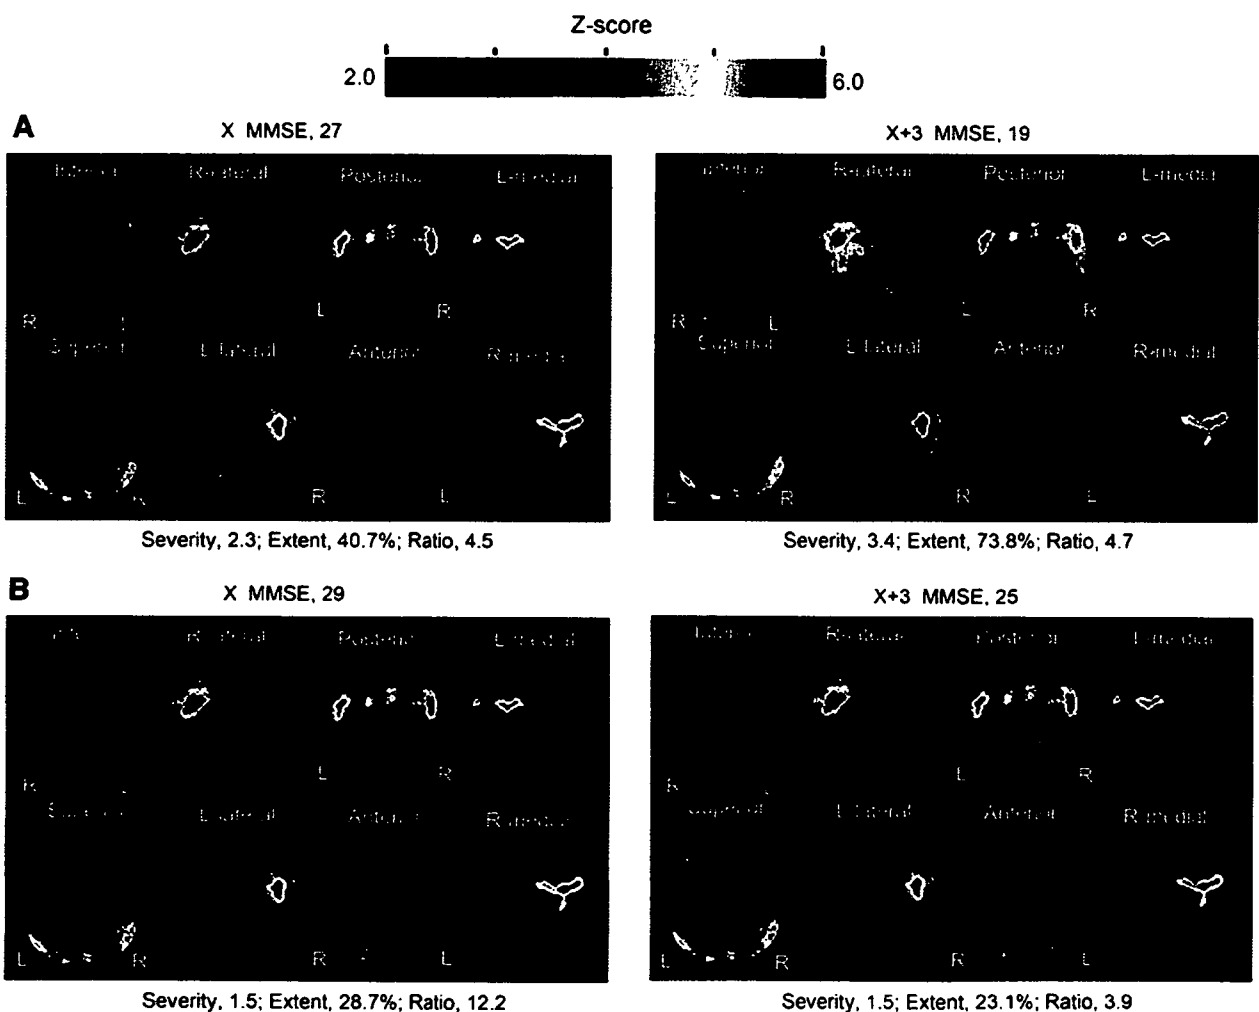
Comparison of z score mapping results for brain perfusion SPECT for converters (from amnesic MCI to AD) and nonconverters over 3 y. (A) For 56-y-old woman who converted from MCI to AD, high values characterizing decreases in rCBF (severity and extent) were seen even at baseline. These values were markedly elevated 3 y later. (B) For 68-y-old man who did not convert from MCI to AD, low values for severity and extent were seen at baseline. These values were not elevated 3 y later. X MMSE = mean score on Mini-Mental State Examination (MMSE) at the initial study; X+3 MMSE = score on MMSE at 3 y.
